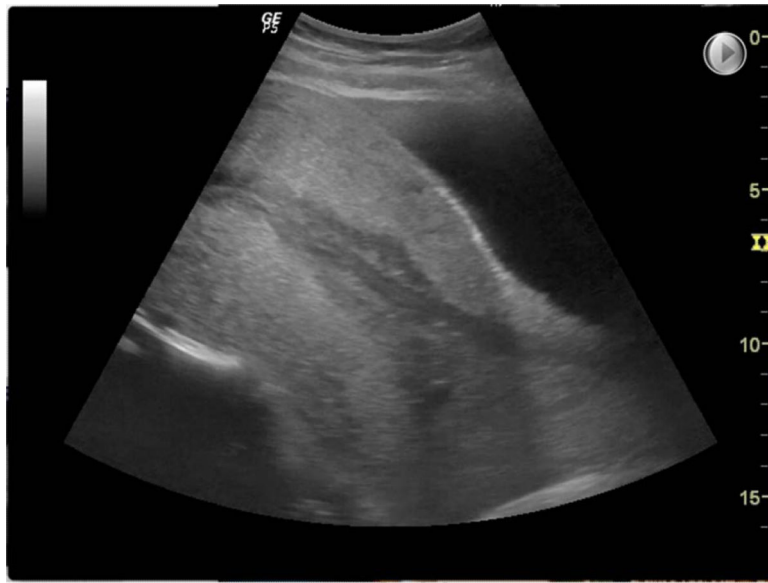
Ultrasound image of empty uterus after instrumental removal of the previously retained placenta.
